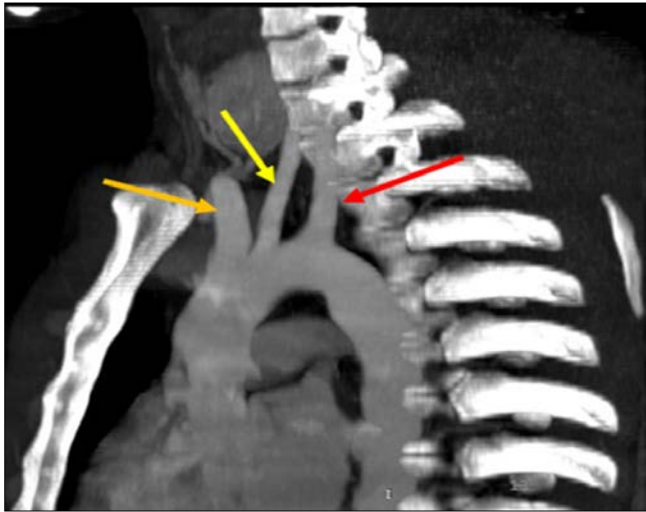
Angio-CT in sagittal section of a standard anatomical configuration of supra-aortic trunk (Type I of the classification by Natsis *et al.*); orange arrow (BCAT); yellow arrow (LCCA); green arrow (LSCA).
